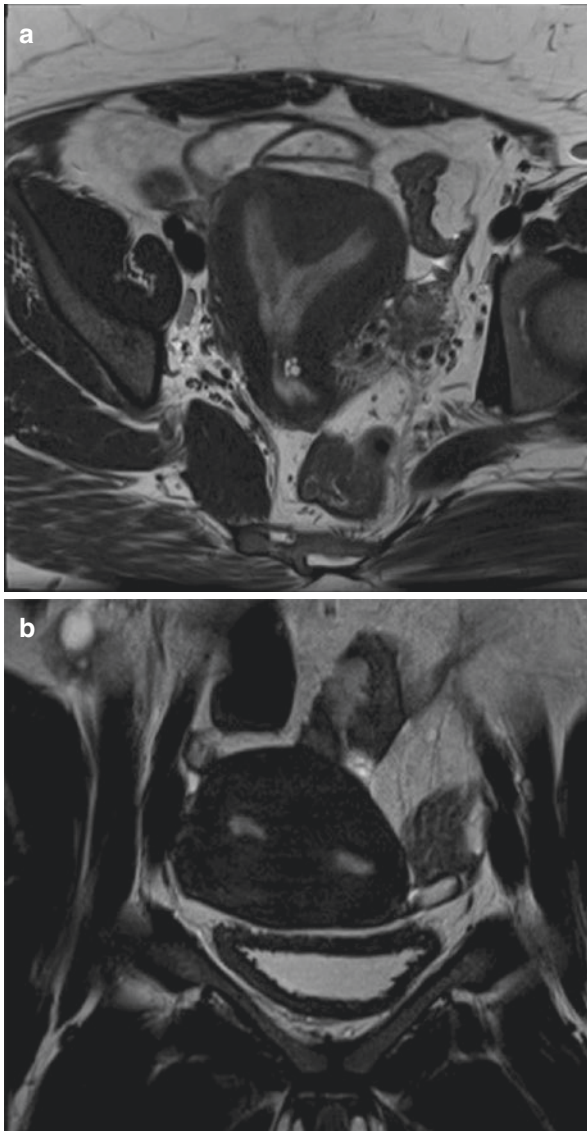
(a) and (b) Axial and Coronal T2-weighted MR images showing a uterine septum (partial). The external fundal contour is normal
